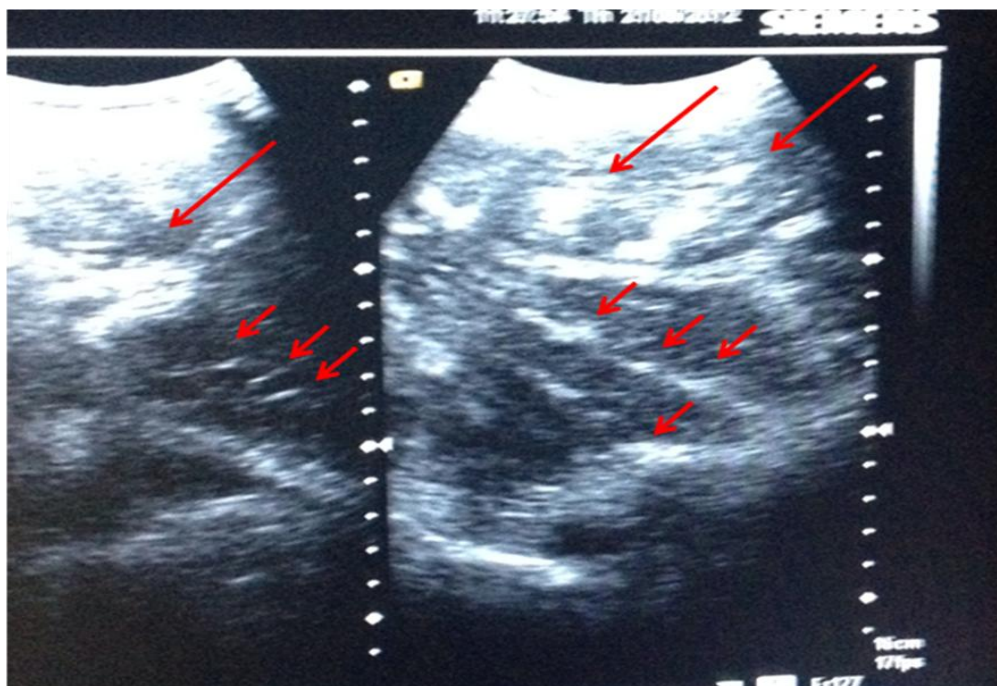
Imagem de ultrassonografia do abdômen com doença hepática crônica mista (fibrose fina difusa pelo parênquima – setas pequenas – e fibrose periportal – setas grandes). Fonte: Cedido pela professora Doutora Ana Lúcia Coutinho Domingues-Gastroenterologia, Hospital das Clínicas, UFPE (2013).
